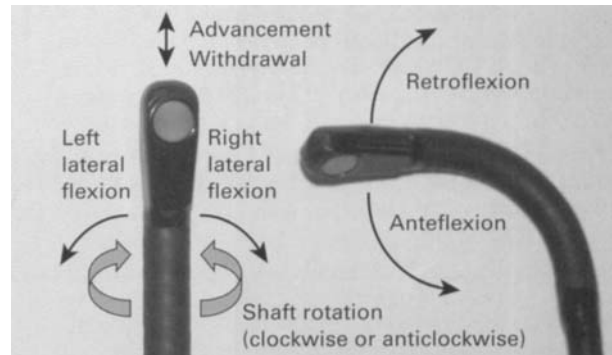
Tip of the multiplane transoesophageal echocardiography probe carrying the ultrasound transducer. The possible movements of the probe are indicated by arrows.
